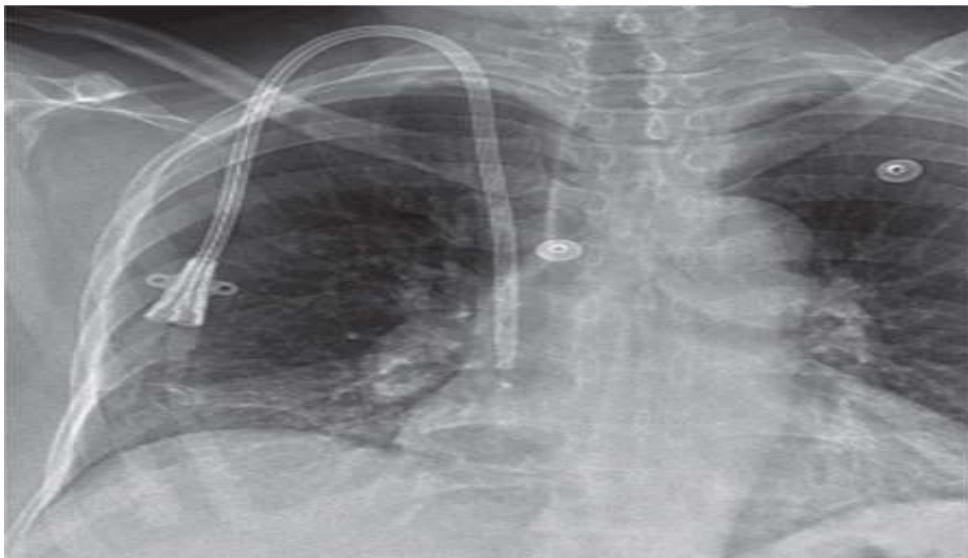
Radiograph of a right internal jugular tunneled central venous catheter with catheter tip placed in right atrium.
